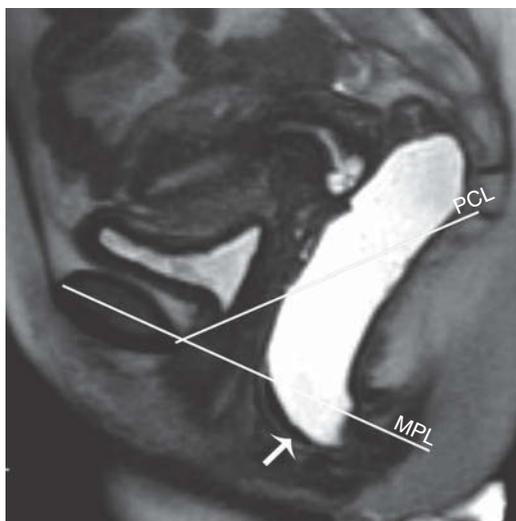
Rectal prolapse in a 53-year-old female. Sagittal T2-weighted SSFSE image obtained during Valsalva maneuver reveals descent of the rectum (arrow) below both the midpubic line (MPL) and the pubococcygeal line (PCL). The anterior inferior anorectal junction is 1.6 cm below the MPL and 5.2 cm below the PCL corresponding to Stage 3 or moderate rectal descent.
